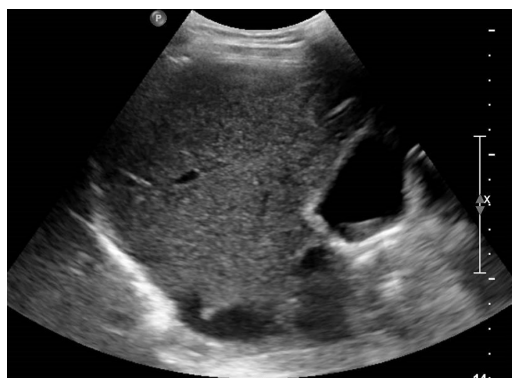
A 46-year-old woman with right hypochondrium pain. Abdominal ultrasound showed an enlarged gallbladder containing deposit of biliary sludge in the infundibular region.
